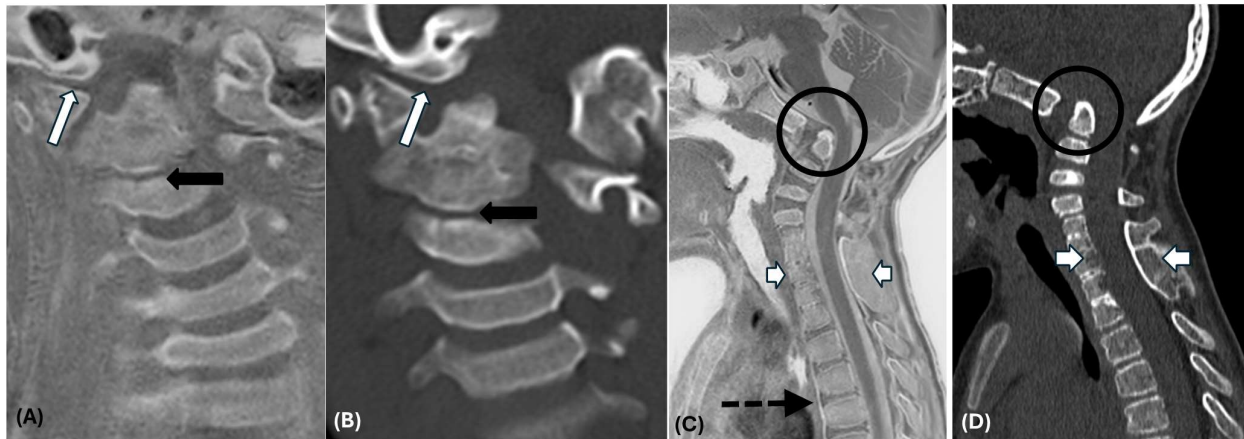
(A) Coronal CS FRACTURE MR mean intensity projection and (B) CT bone window images of a 5-year-old with KF anomaly show right occipital condyle hypoplasia (long white arrows), partial fusion of C2-C3 vertebrae (black arrows) and their posterior elements (not shown) resulting in left torticollis. (C) Sagittal CS-FRACTURE MR and (D) CT bone window in a 6-year-old with KF anomaly show fusion of multiple cervical vertebrae (short white arrows), atlantooccipital assimilation, hypoplastic dens and basilar invagination (black circle). In addition, the acute angulation and effacement of the anterior CSF space at the cervico-medullary junction caused by the changes at the craniovertebral junction are well seen on FRACTURE MRI. The ligaments show a similar bright signal as CSF (dotted black arrow in 2c for anterior longitudinal ligament).
